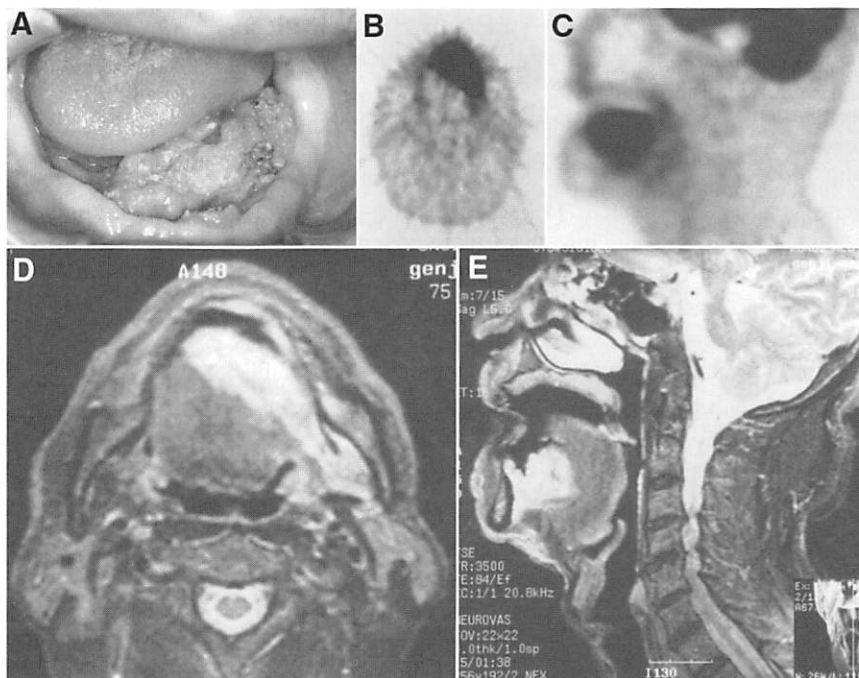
Male patient (74-y-old) with large squamous cell carcinoma on floor of left side of mouth (A). FDG PET of axial (B) and sagittal (C) views shows high accumulation of radioactivity (SUV = 14.54 mg/mL) on floor of mouth, consistent with MRI findings (D and E).
